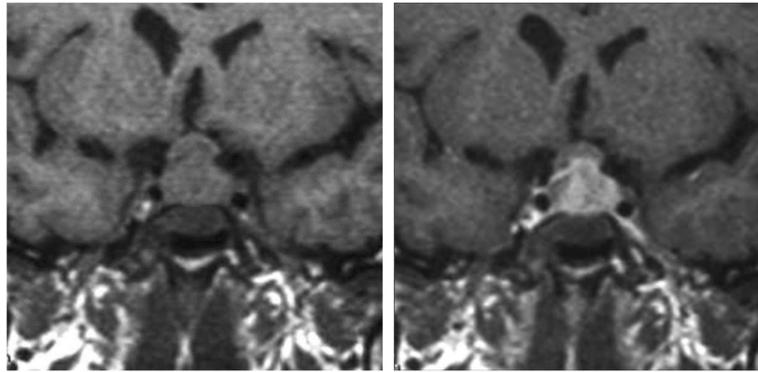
Coronal T1-weighted (left) and contrast (right): Sellar/suprasellar mass, isointense T1 and hyper/hypo-intense in T2 to white matter, with mass effect on the undersurface of the optic chiasm. Mass demonstrates heterogenous enhancement
